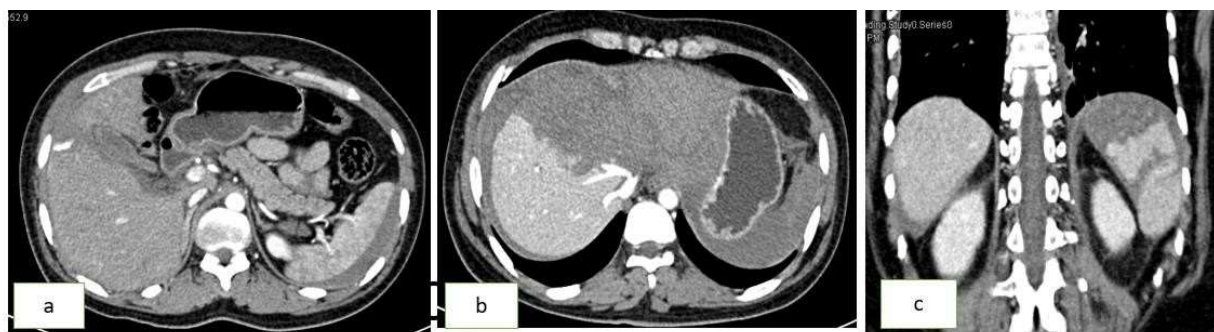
Contrast CT abdomen showing (a ) grade IV liver injury with active bleed(b) grade V liver injury and (c) grade IV splenic injury
